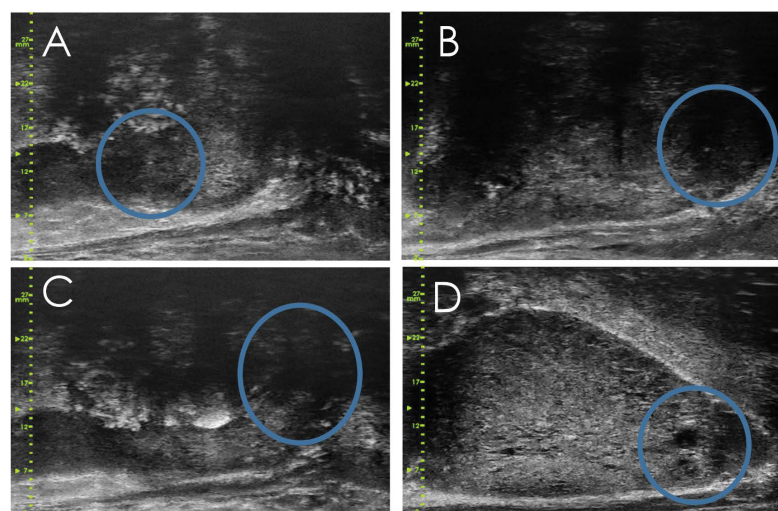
Lesions prospectively identified on micro-ultrasound only. PRI-MUS lesions are circled in blue. (A) PRI-MUS 3 (mild heterogeneity) lesion found to contain 5% Gleason 7. (B) PRI-MUS 3 (mild heterogeneity) lesion found to contain 10% Gleason 7. (C) PRI-MUS 3 (mild heterogeneity) found to contain 5% Gleason 7. (D) PRI-MUS 5 (mixed echo lesion) found to contain 5% Gleason 7.
